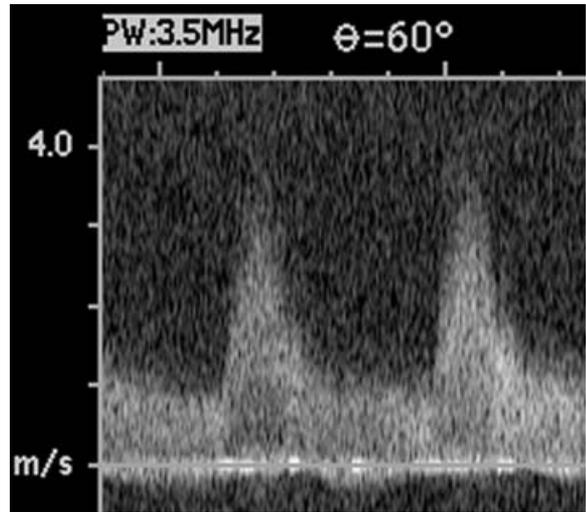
Spectral Doppler of left subclavian artery very high peak systolic velocity (370 cm/sec) and the presence of abnormal antegrade flow during diastole (end-diastolic velocity of 90 cm/sec) are indicative of significant subclavian artery stenosis. On 2D imaging (not shown), there was a 50%-diameter stenosis.
